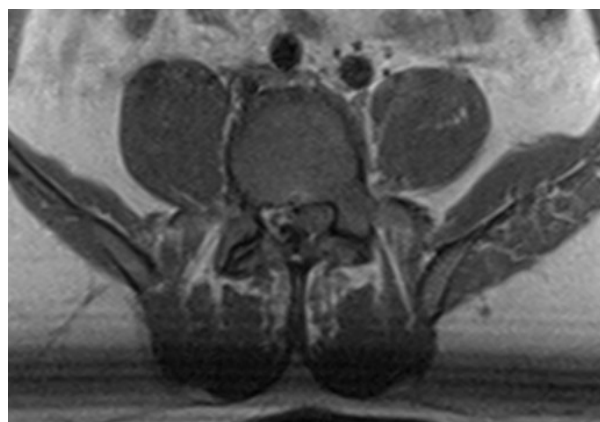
MRI Lumbar Spine T1 Axial
